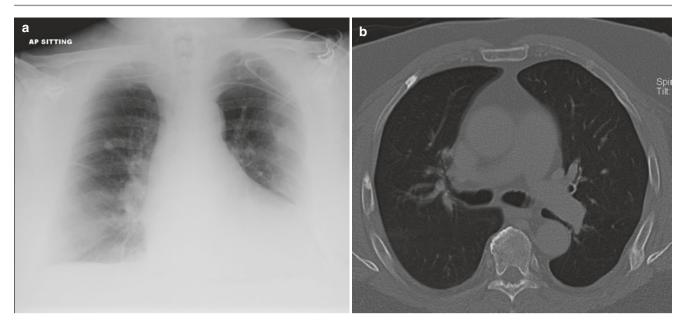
Focal rib sclerosis mimicking nodule. (a) Frontal chest radiograph shows a nodule projecting over the right mid-zone. (b) Axial CT image reveals a vague sclerotic focus located in the rib accounting for the nodular shadow on the radiograph
